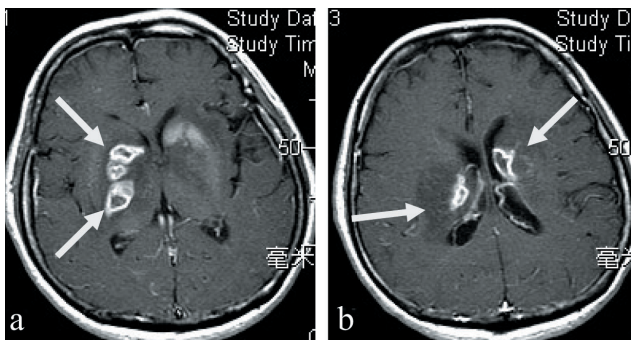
Gadolinium contrast-enhanced T1-weighted images show multiple lesions with rimmed-enhancement at the areas of bilateral basal ganglia (arrow)
